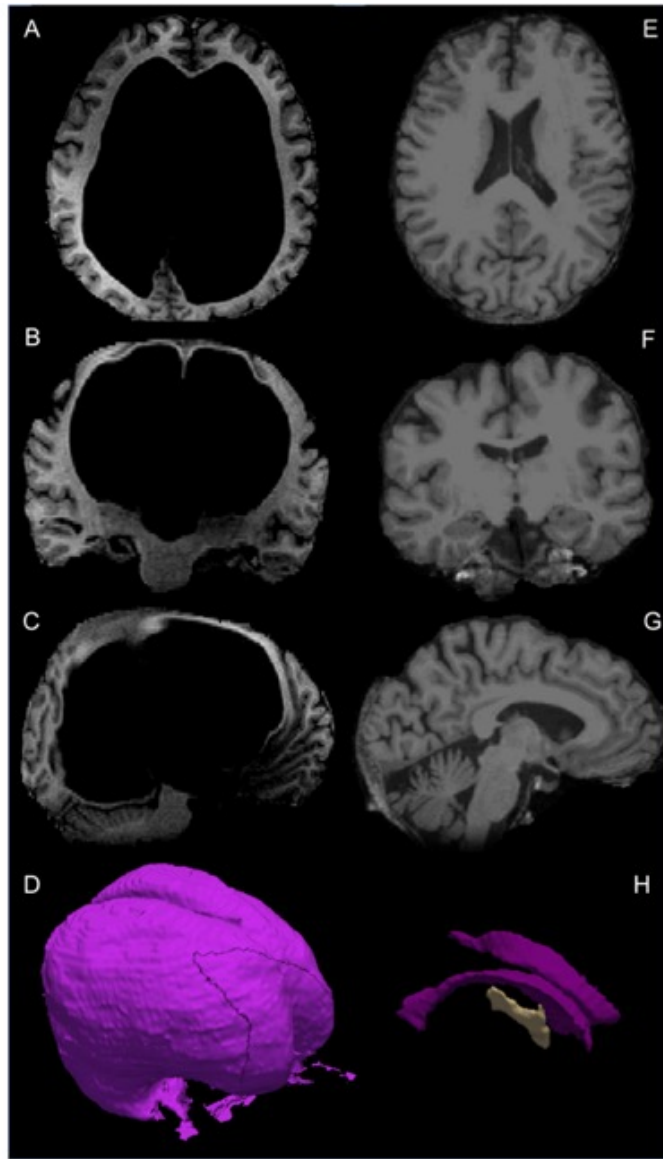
From top to bottom: T1-weighted magnetic resonance imaging (MRI) images in the transverse, coronal, and sagittal planes of Patient CS (A-C) and a healthy age- and sex-matched control participant healthy control 1 (HC1) aged 60 (E-G). Three dimensional image of Patient CS' ventricular space (D), and (H) three dimensional images of left and right lateral, and third ventricles taken from the Freesurfer (Dale et al., 1999) average of 35 brains template.
